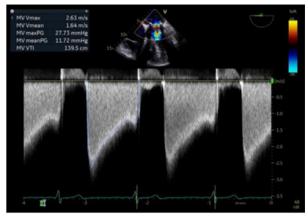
Pre-procedure transesophageal echocardiogram (TEE): Continuous wave inflow Doppler of mitral valve on TEE showing severe stenosis of bioprosthetic mitral valve with a mean gradiant of 11.72 mmHg.
